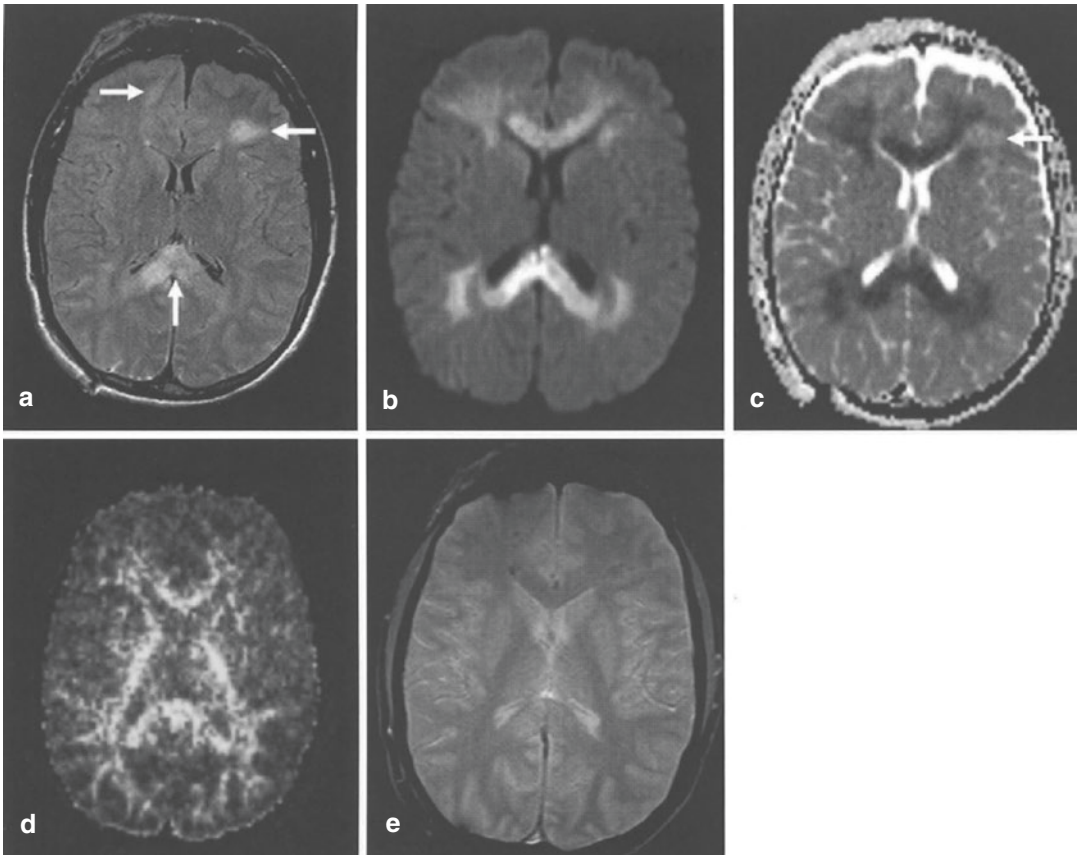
(a–e) Diffuse axonal injury in a 24-year-old man after a motor vehicle accident. (a) FLAIR image shows multiple asymmetric hyperintense lesions in the bilateral frontal white matter and the corpus callosum (arrows). (b) DW image shows diffuse hyperintense lesion in the deep white matter and the corpus callosum. (c) ADC map reveals decreased ADC in the deep white matter and the corpus callosum. The left frontal lesion
